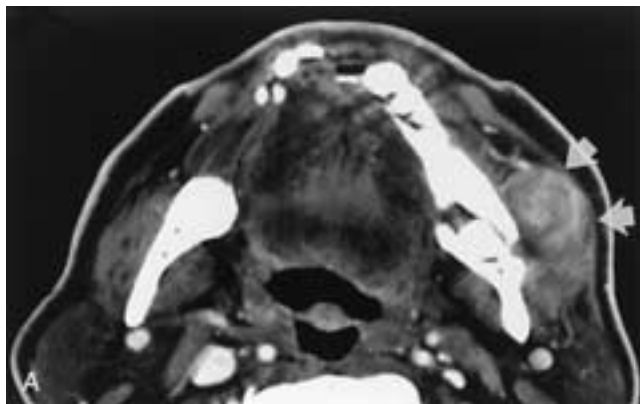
Masseter muscle myositis. A, Contrast-enhanced axial CT scan demonstrates enlargement and enhancement of the left masseter muscle, which causes bulging of the platysma muscle laterally (arrows). B, Same image viewed at bone window settings shows evidence of osteomyelitis (arrows).
